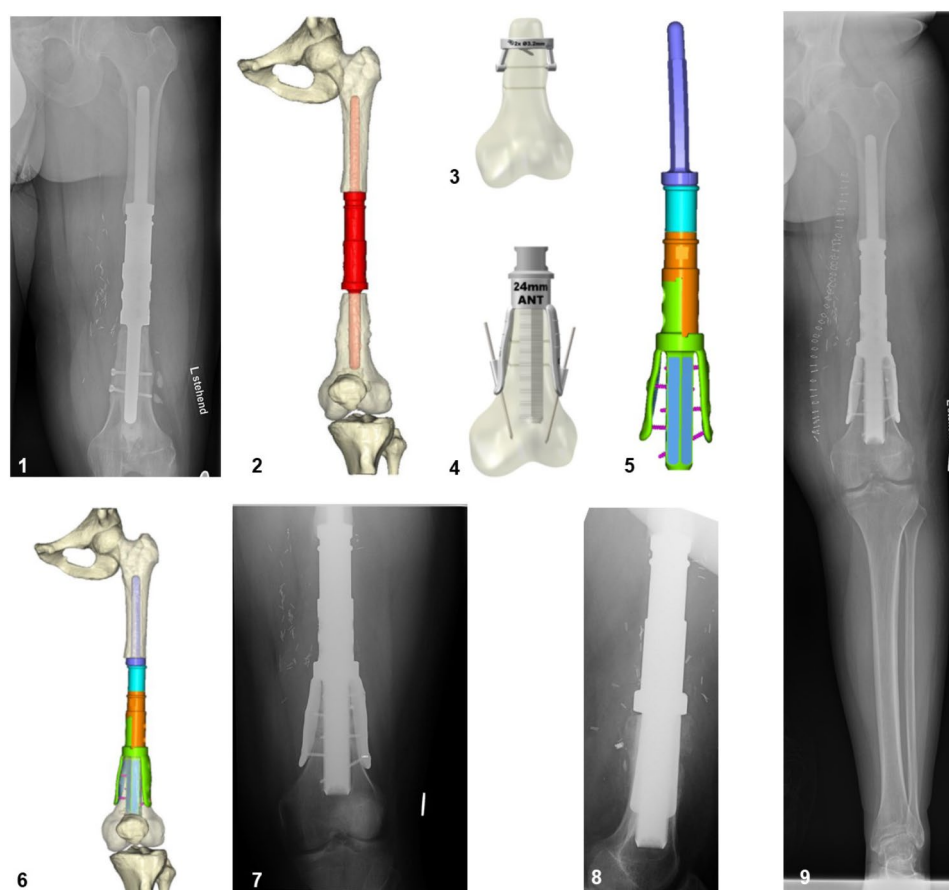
32-year-old patient presenting with an aseptic loosening of an intercalary implant due to a primary osteosarcoma after 6 years; Image 1: Preoperative x-ray; Image 2: generated 3D model; Image 3 and 4: Planned PSI; Image 5: Planned implant; Image 6: Planned reconstruction; Image 7 and 8: Follow-up at 6 months; Image 9: Postoperative lower extremity x-ray
